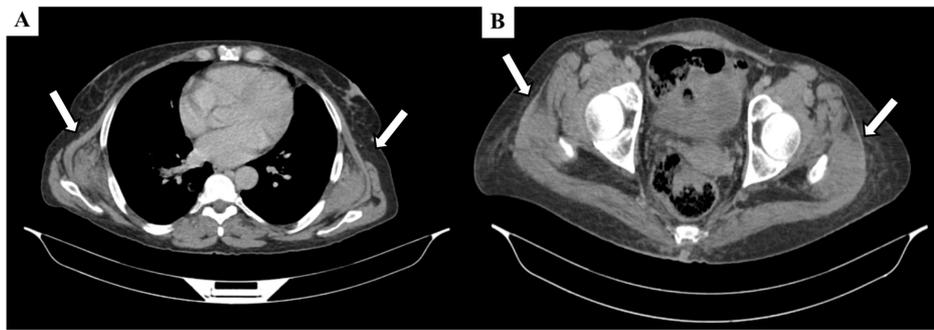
Follow-up contrast-enhanced CT (axial view) showing stability of bilateral elastofibromas on March 19, 2025
